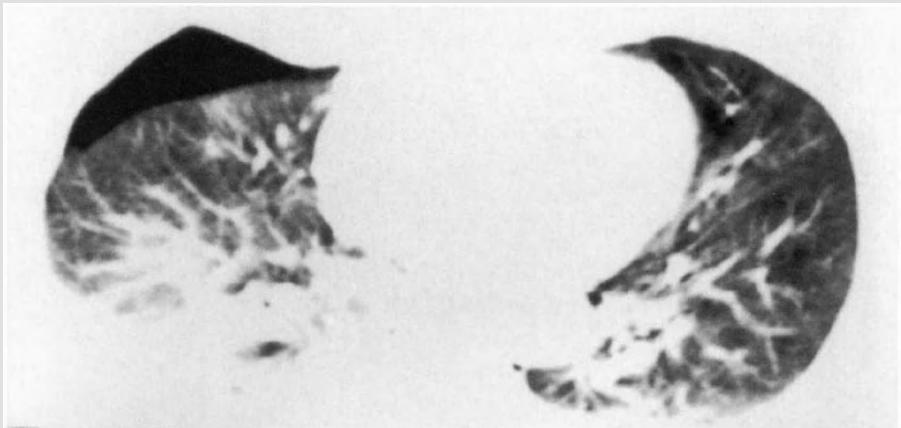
Pneumothorax. In the supine position a small pneumothorax is best seen with CT
